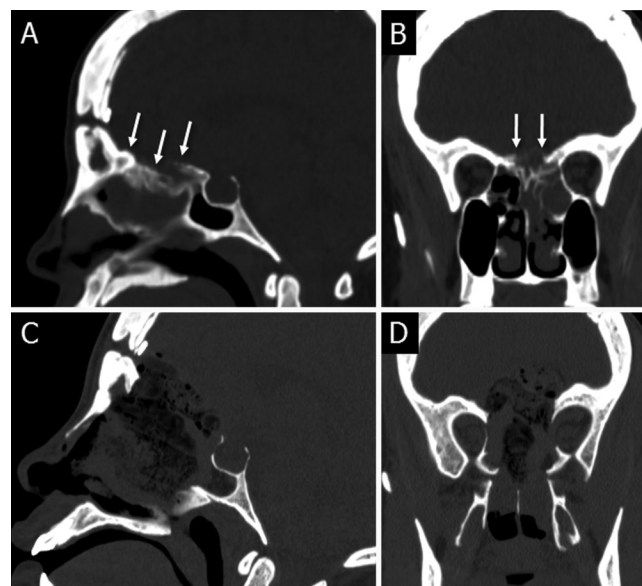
Case 2. A and B: Preoperative sagittal (A) and coronal (B) CT reconstructions showing recurrence with extensive hyperostosis at the ventral skull base (white arrows). Note the previous bifrontal craniotomy defect at the frontal sinus. C and D: Postoperative sagittal (C) and coronal (D) CT reconstructions (after an endoscopic endonasal approach) demonstrating a maximal ventral skull base defect extending from the posterior table of the frontal sinus to the anterior sella in the sagittal view, and from medial orbit to medial orbit in the coronal view.
